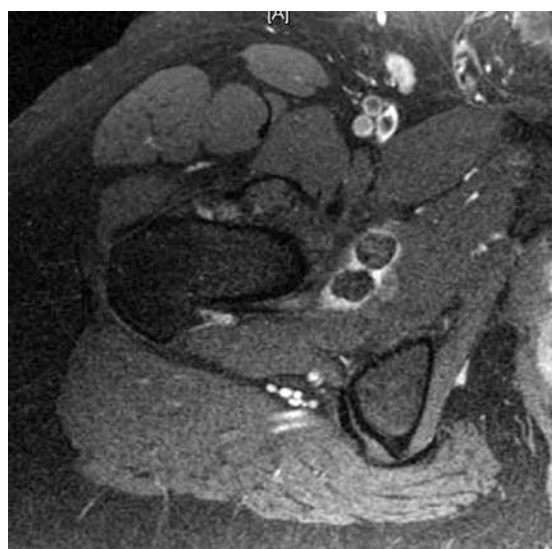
Axial contrast-enhanced fat saturated T1-W MR image of the right hip.
